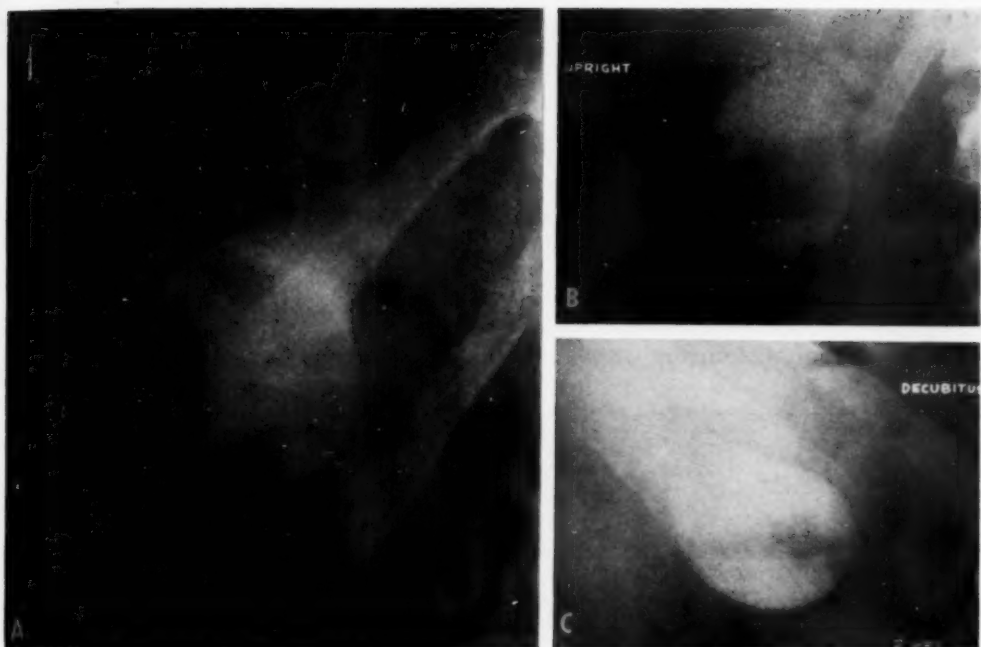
A. Roentgenogram obtained eighty minutes after injection of Cholografin, with the patient prone. A peculiar circular area of radiolucency is apparent in the partially filled gallbladder. B and C. Stratification phenomenon demonstrated at two hours in upright and right lateral decubitus positions.
